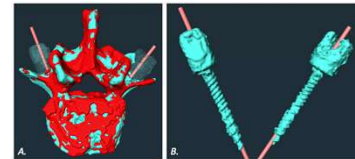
OnPoint Alm-AR system: A. Registration of pre-operative CT or intra-operative spin (cyan) with post-operative CT (red). B. Comparison of post-operative screw position (cyan) with intra-operatively planned trajectories (pink).
